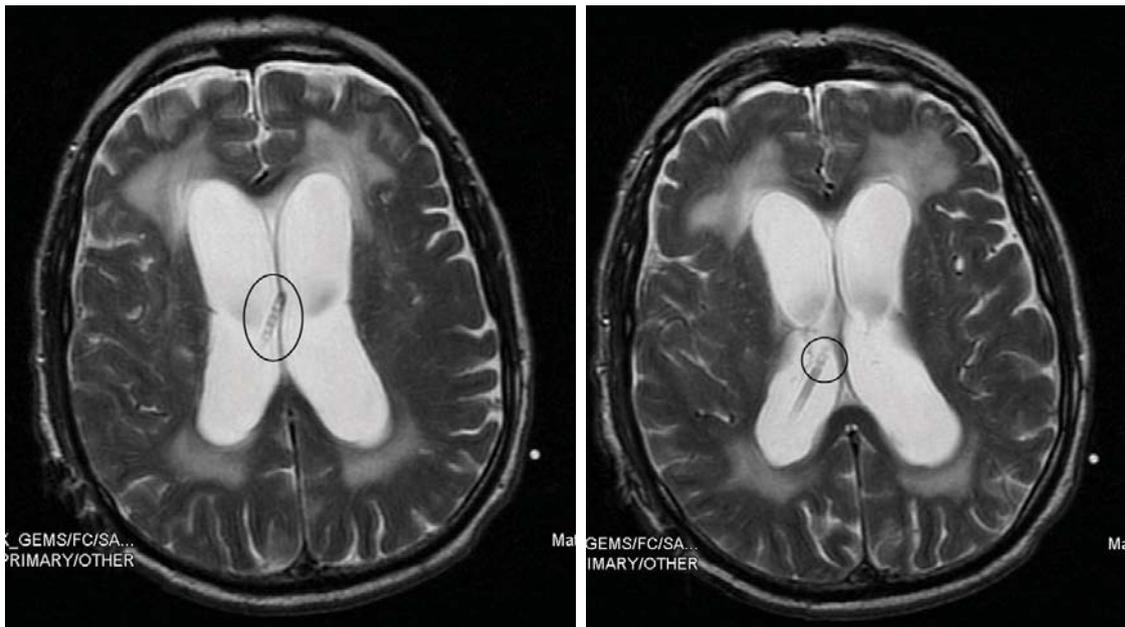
Brain MRI scans. Axial views.
